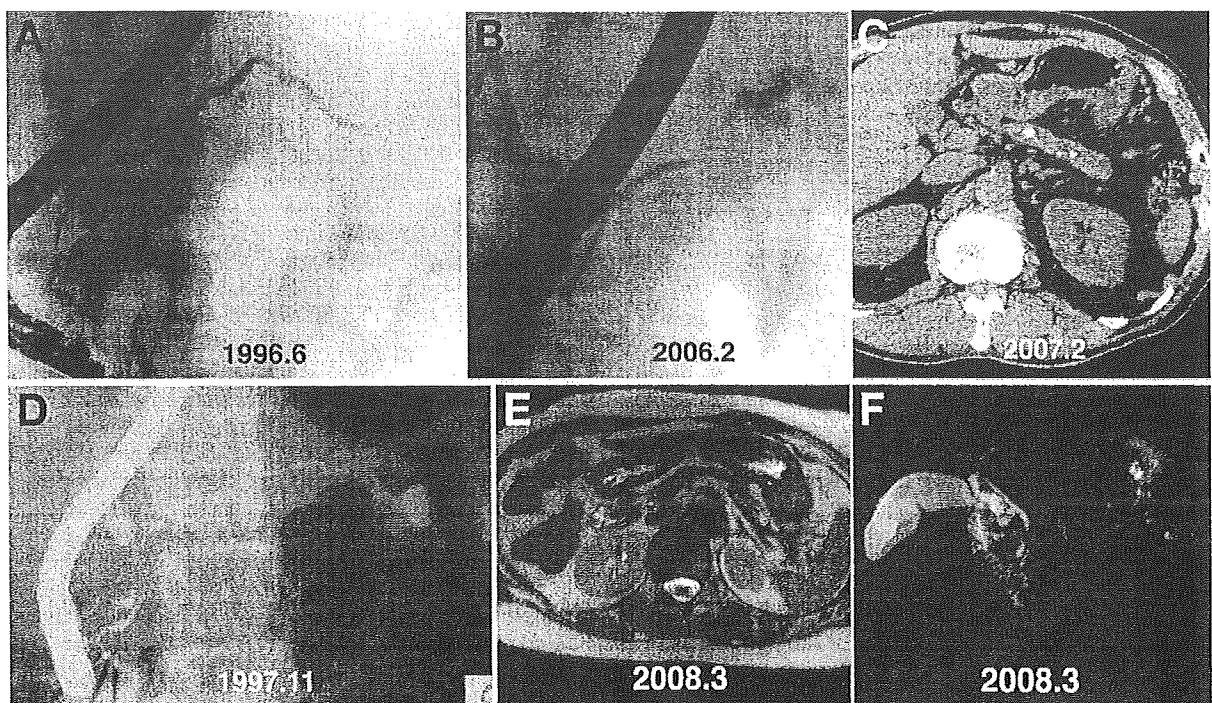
Image findings from 55-year-old man with AIP who had high serum IgG4 concentrations. A pancreatic stone appeared after several recurrences during 10-year follow-up. (A) ERP at onset showed irregular narrowing of the head region of the pancreas; (B) 10 years after onset, ERP image of MPD showed narrowing in the body and dilatation in tail region. (C) Pancreatic stone appeared in the body and tail regions of MPD after reduction in prednisolone dose. For comparison, lower panels show image findings for 65-year-old woman with AIP who had normal serum IgG4 concentrations during 10 years of follow-up. (D) ERP performed at onset shows diffuse irregular narrowing of MPD; (E) MRI and (F) MRI of pancreas showed no progression or duct changes in 10 years of follow-up.
